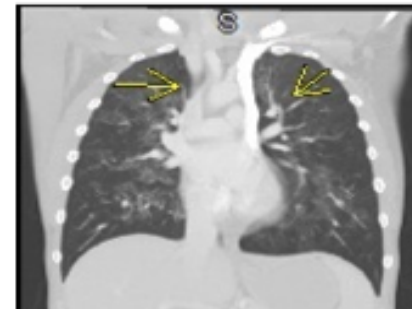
Our patient's CT showed centrally located groundglass densities involving bilateral upper and lower lobes with relative sparing of the subpleural lung. Subcentimeter hilar and mediastinal lymph nodes were noted without evidence of pneumonia, mass, cavitary lesion.
